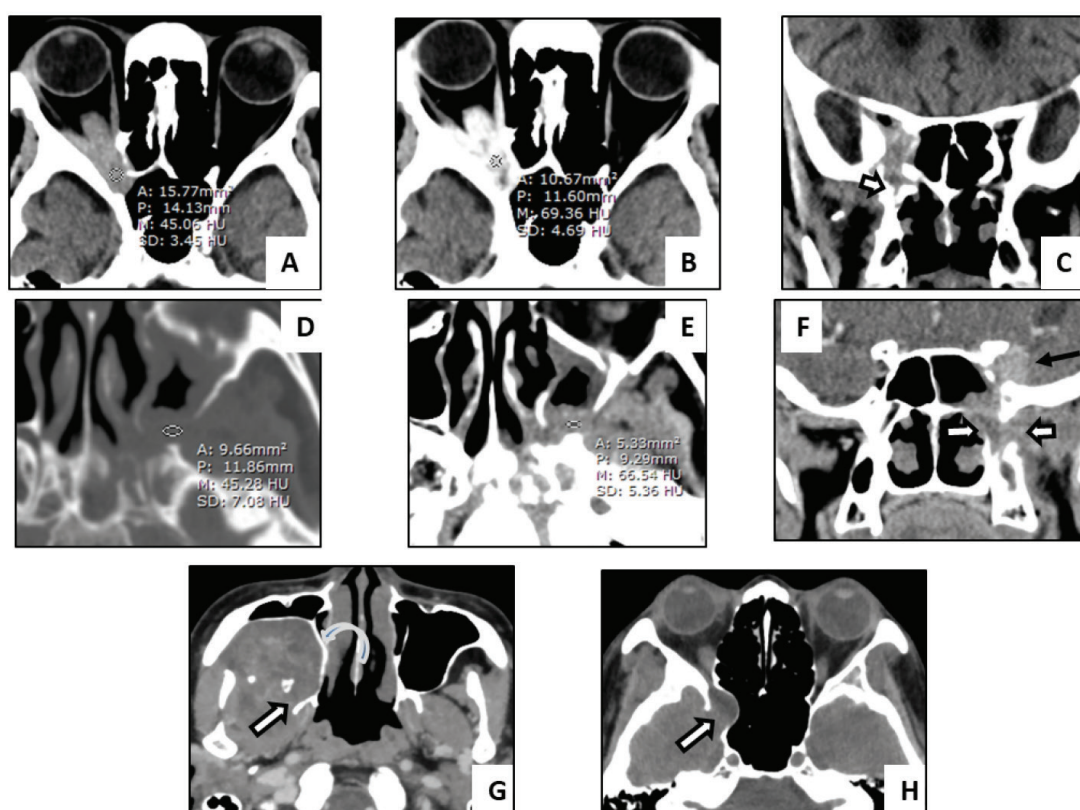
A, B and C: A 80-year-old man with invasive aspergillosis rhinosinusitis was interpreted as malignant soft tissue tumor. The lesion shows isodense on non-contrast CT (A) with solid contrast enhancement (B and C) at right orbital apex and PPF with adjacent bony destruction (arrow in C). D, E and F: A 50-year-old woman with chronic inflammation (unidentified pathogen) was interpreted as malignant soft tissue tumor. The lesion appears as an ill-defined enhancing mass (D and E) at left PPF (open arrow in F) and left cavernous sinus (arrow in F) with bony destruction. G and H: A 47-year-old woman with schwannoma was interpreted as benign soft tissue tumor. There is a heterogeneous enhancing mass at right masticator space with bone remodeling of right maxillary sinus (curve arrow in G) with widening of right PPF (open arrow in G) and inferior orbital fissure (open arrow in H)
